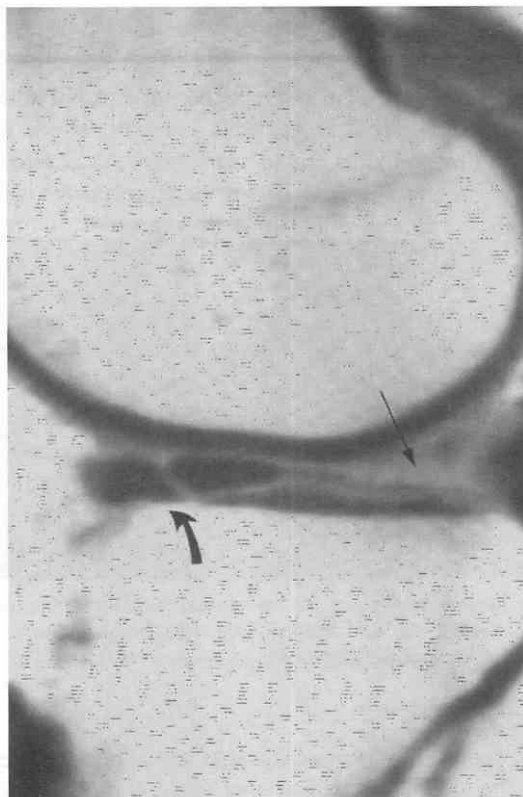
Displaced meniscal tear. Sagittal T1-weighted image shows virtual absence of the posterior horn of the lateral meniscus (straight arrow). The displaced fragment (curved arrow) has flipped anterior to the anterior horn of the lateral meniscus.
